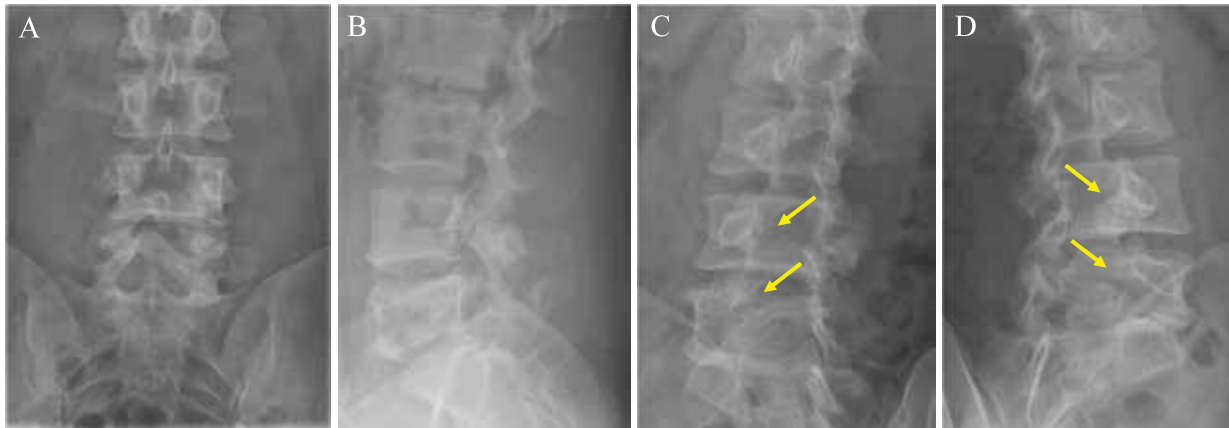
Preoperative anteroposterior (A), lateral (B), right oblique (C), and left oblique (D) radiographs demonstrating bilateral lumbar spondylolysis at L4 and L5 in a 26-year-old man.
